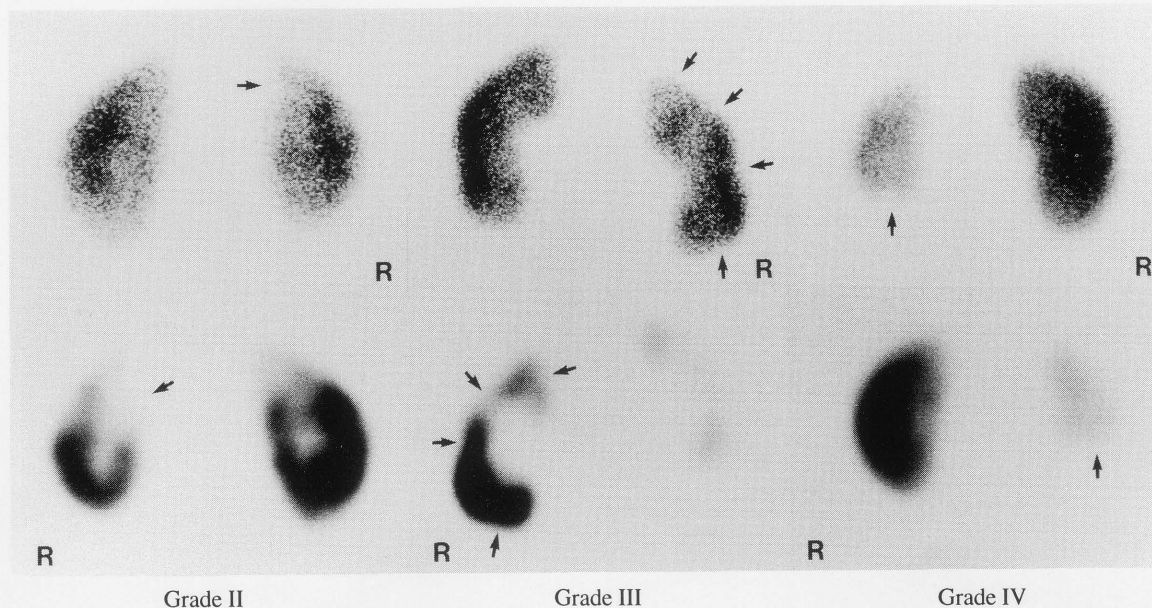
Examples of the scintigrams of grade II, III and IV. Upper columns: planar images. Lower columns: SPECT images without renal axis correction.
